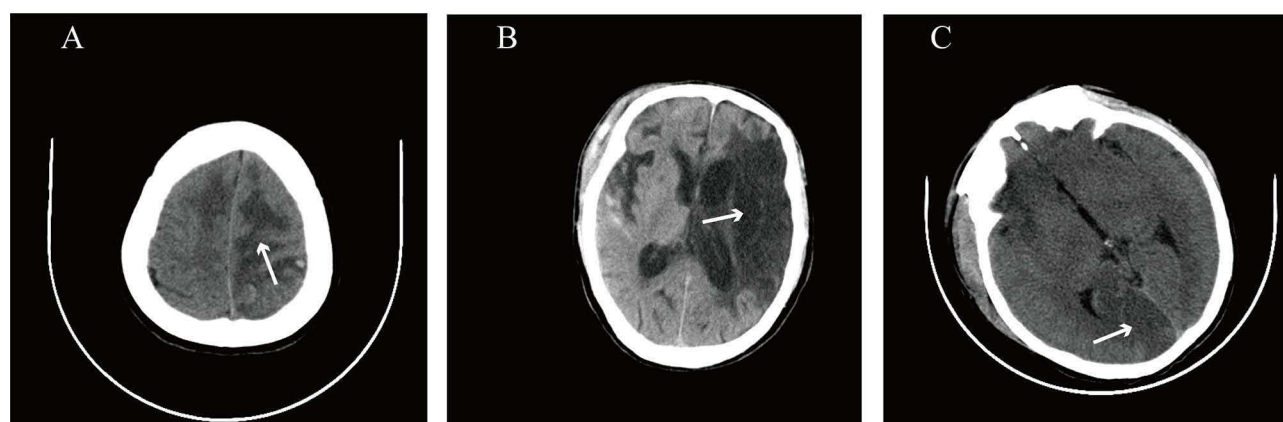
Different locations of cerebral infarction in CT after traumatic brain injury. The area indicated by the white arrow relative to the surrounding black area represents the area of cerebral infarction. (A). Low-density infarct lesions in the region innervated by the anterior cerebral artery; (B). Low-density infarct lesions in the region innervated by the middle cerebral artery; (C). Low-density infarct lesions in the region innervated by the posterior cerebral artery.
